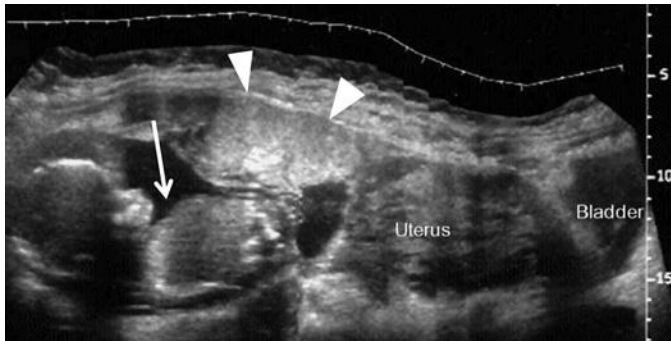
Abdominal pregnancy. Transabdominal longitudinal extended field of view ultrasound image of the abdomen and pelvis of a woman with a term fetus (*arrow*) located in an amniotic sac located well above the uterine fundus. Surgery was performed and resulted in delivery of a live, healthy newborn. Placental tissue is located anteriorly (*arrowheads*) implanted into the peritoneum of the anterior abdominal wall. (From TheFetus.net, used with permission.)
